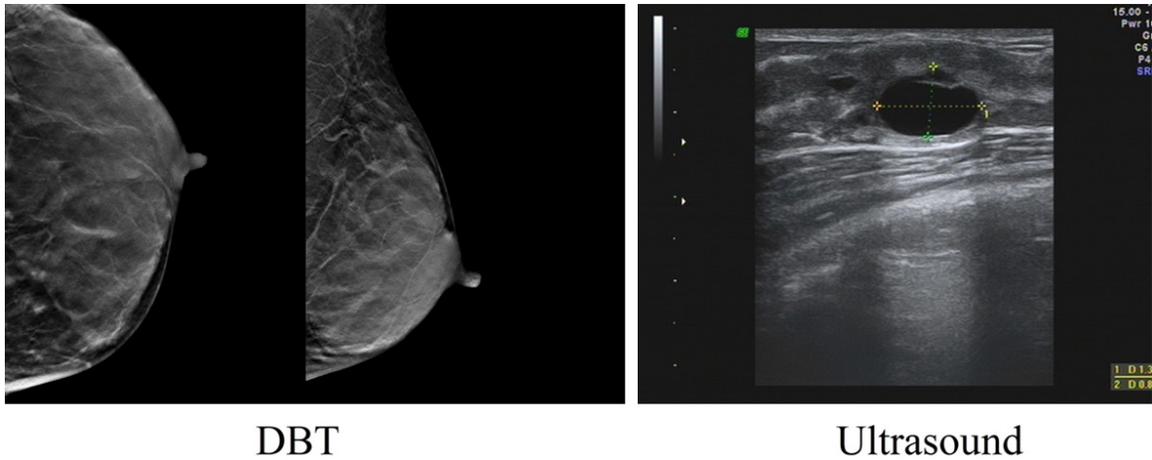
DBT and ultrasound for breast cystic lesions. DBT, digital breast tomosynthesis.
